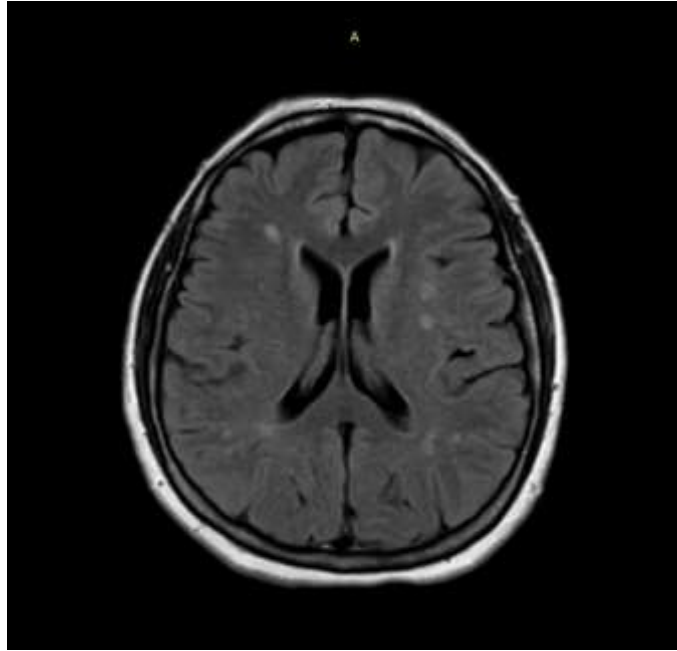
MRI brain-IAC FLAIR-long TR axial image for patient number 17 shows labyrinthitis ossificans , non-specific white matter disease.
